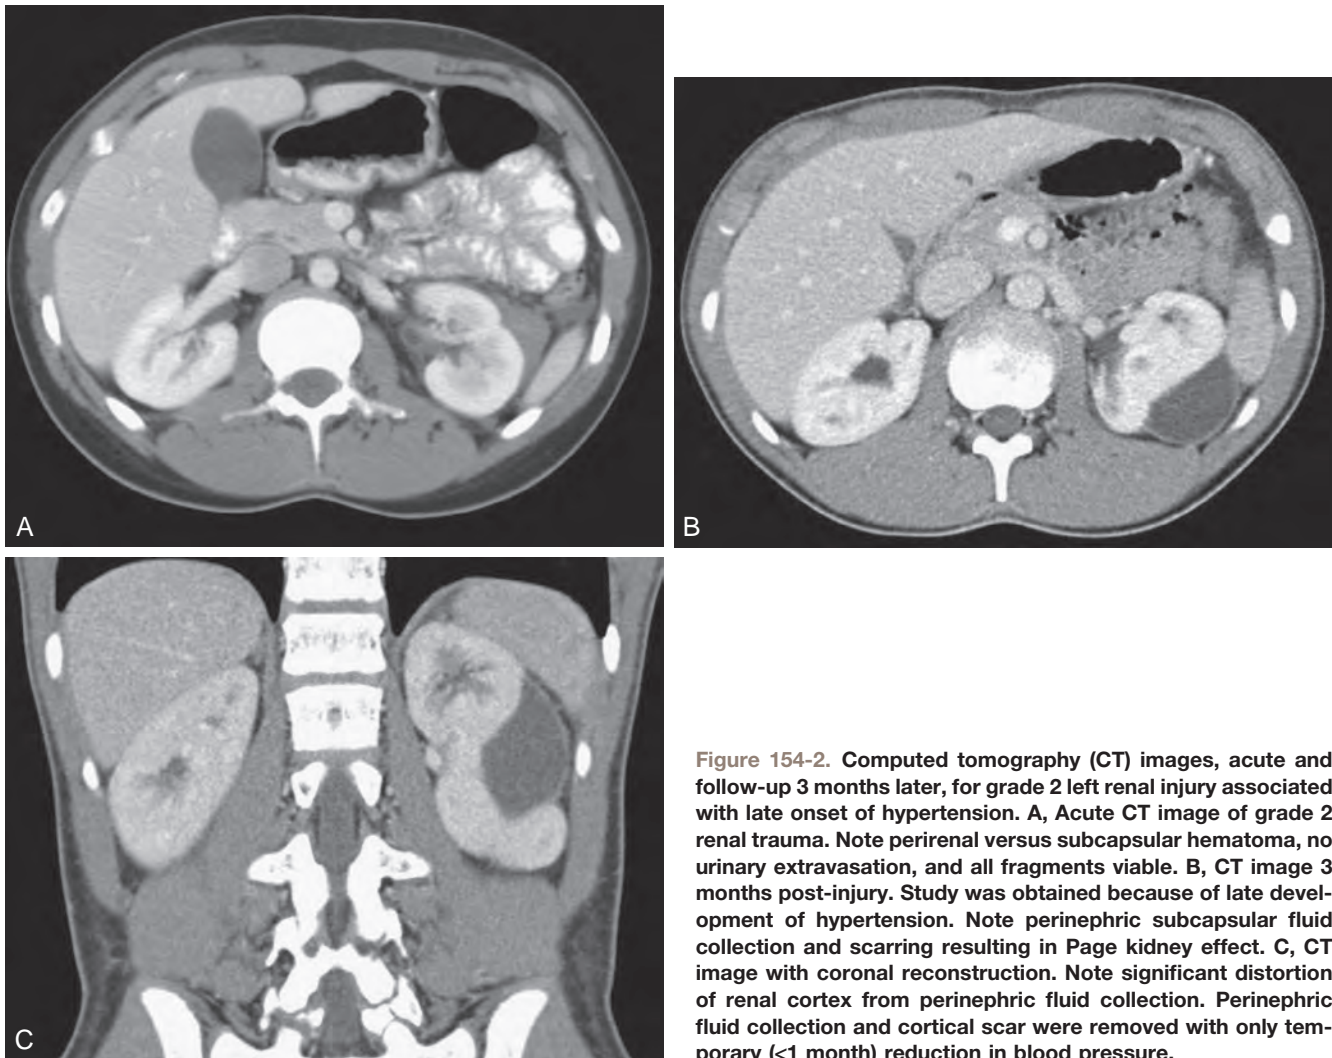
Computed tomography (CT) images, acute and follow-up 3 months later, for grade 2 left renal injury associated with late onset of hypertension. A, Acute CT image of grade 2 renal trauma. Note perirenal versus subcapsular hematoma, no urinary extravasation, and all fragments viable. B, CT image 3 months post-injury. Study was obtained because of late development of hypertension. Note perinephric subcapsular fluid collection and scarring resulting in Page kidney effect. C, CT image with coronal reconstruction. Note significant distortion of renal cortex from perinephric fluid collection. Perinephric fluid collection and cortical scar were removed with only temporary (<1 month) reduction in blood pressure.
